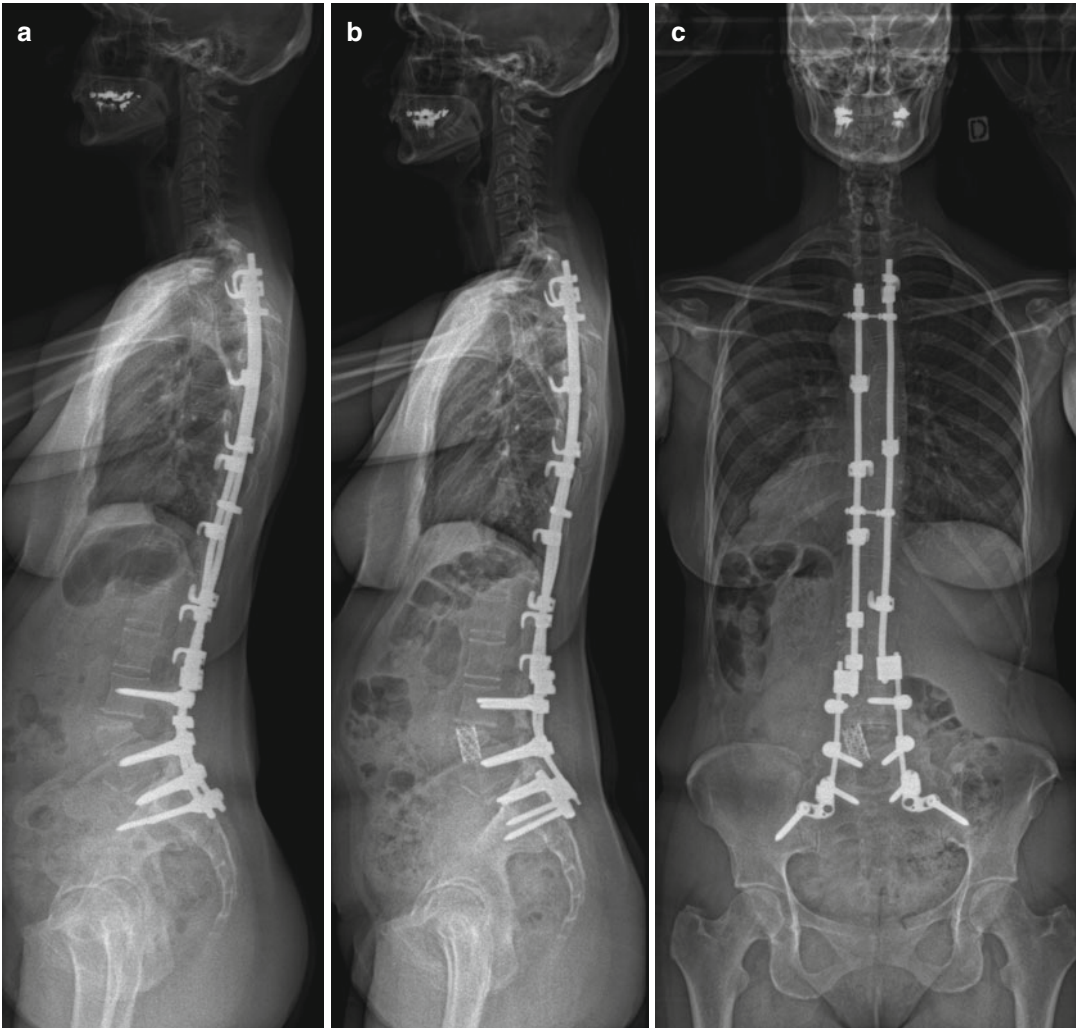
Preoperative radiographs of one patient after lumbar PSO. (a) Postoperative radiographs of the patient after partial corpectomy on L4 by OLIF approach (b, c)
